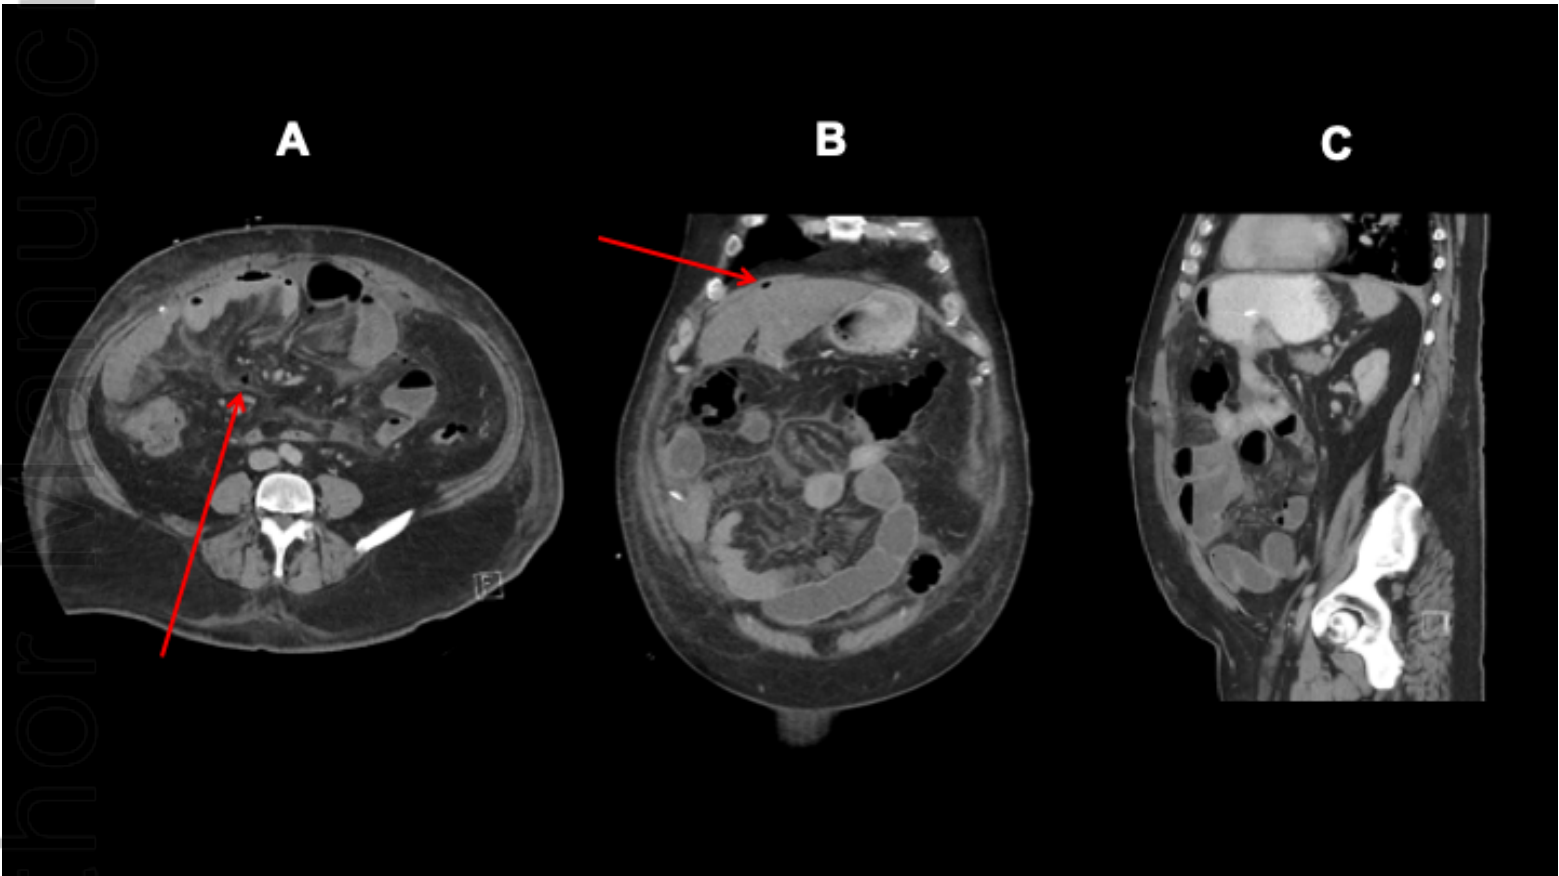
Axial (A), coronal (B) and sagittal (C) CT images three days following relook laparotomy and removal of the jejunal feeding tube. The imaging shows complete resolution of the enteric and mesenteric pneumatosis. Sparse extraluminal locules of gas (arrows) and inflammatory changes in the small bowel mesentery represent post-operative changes.
